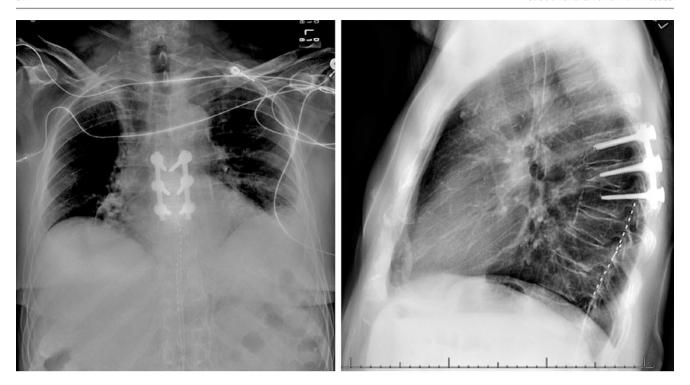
(a, b) AP and lateral view chest X-ray: Termination of electrodes at T8 and T10 confirms the absence of obvious lead migration. Images from personal library
